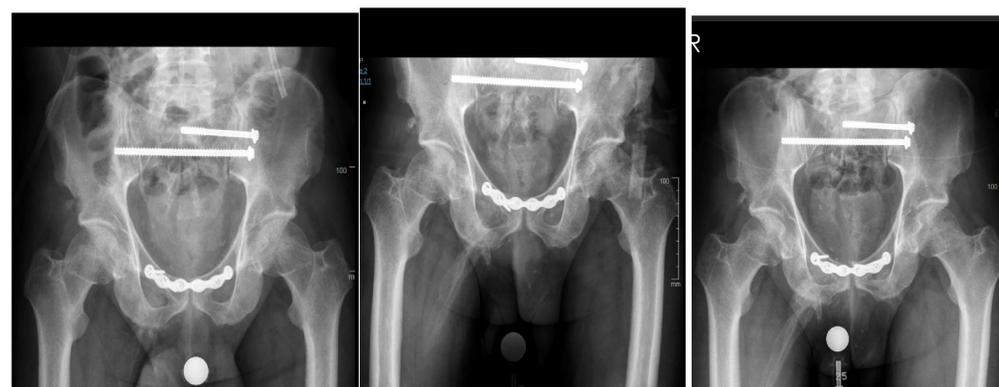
Xray progress of HO from left to right, 10/2018, 12/2018 to 7/2019
